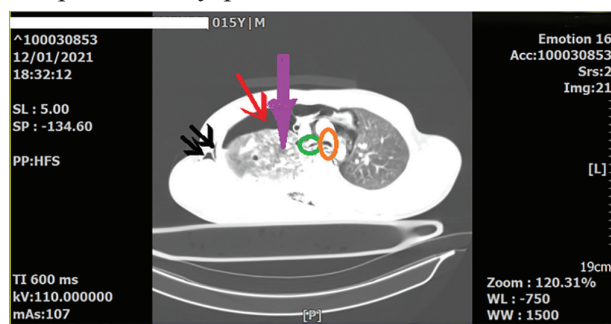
Axial plane view of the chest CT on lung window shows right-sided subcutaneous emphysema (black arrows), right pneumothorax (red arrow), and lung (purple arrow). The left main bronchus silhouette is intact (brown circle), while the outline of the right main bronchus is disrupted (green circle).
